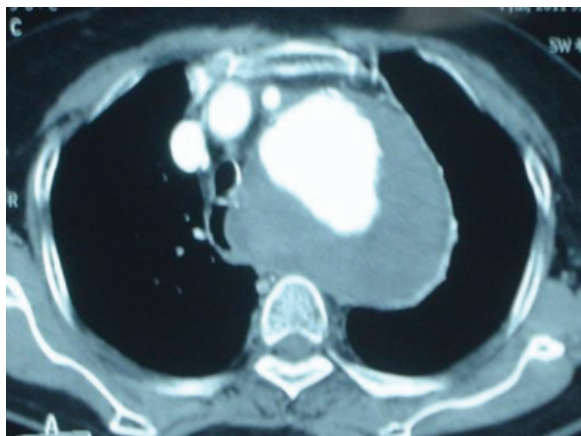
Computed tomography scan revealed a large saccular aortic arch aneurysm compressing the esophagus.
